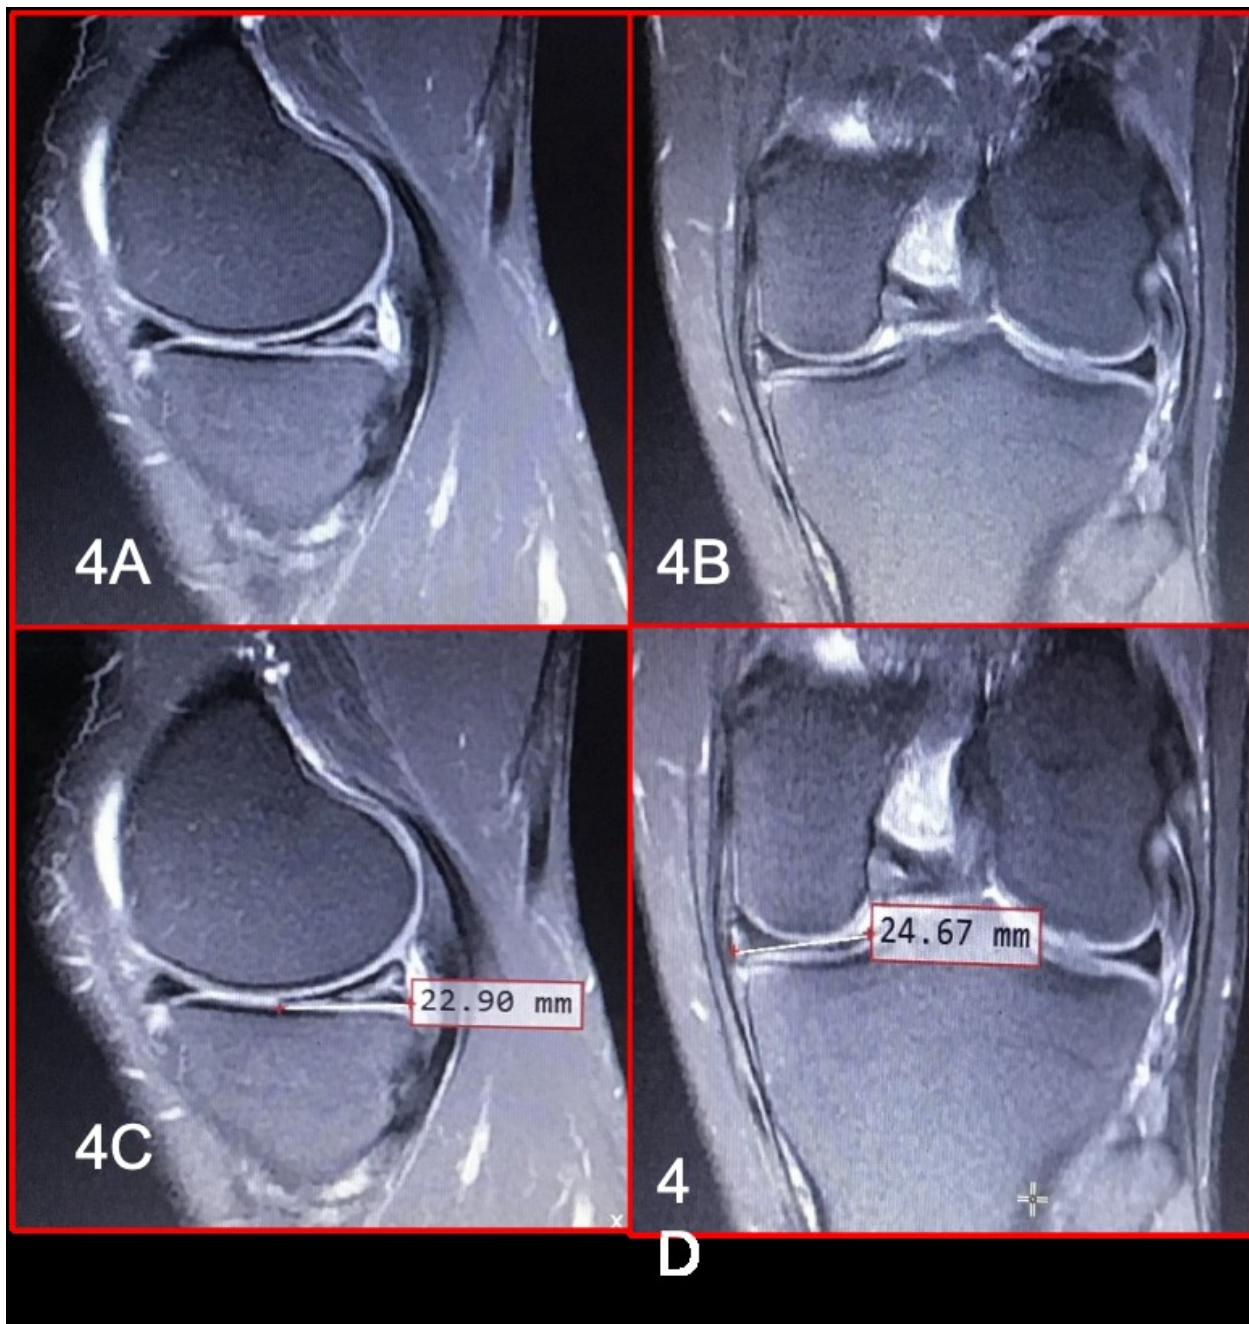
MRI images showing a complete oblique tear of the posterior horn of the medial meniscus with associated parameniscal cyst. Sagittal T2 FS (4A) and coronal PD FS (4B) images demonstrating an oblique tear extending from the meniscocapsular junction to the inferior articular surface. Sagittal T2 FS (4C) and coronal PD FS (4D) images showing enlarged posterior horn measurements of 20 mm (anteroposterior) and 23 mm (transverse).
